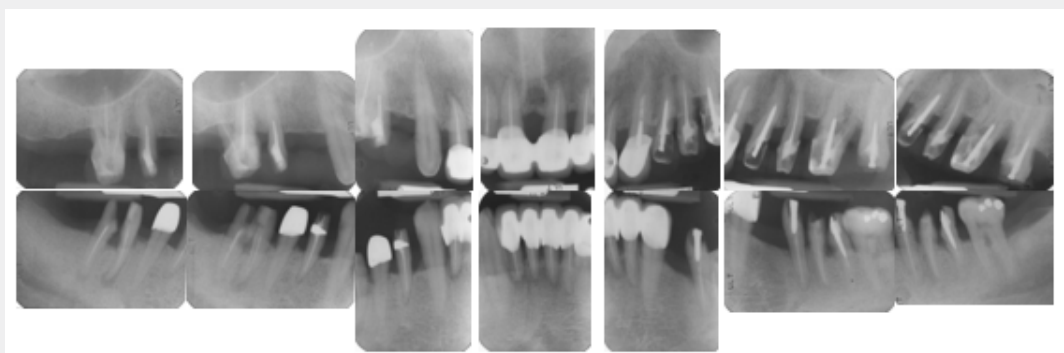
The full mouth radiographic alveolar bone and periodontal parameters of patient revealed remarkable periodontal bone regeneration treated using combined periodontal, prosthetic and SOT treatments after two years (9/16/ 1996).
